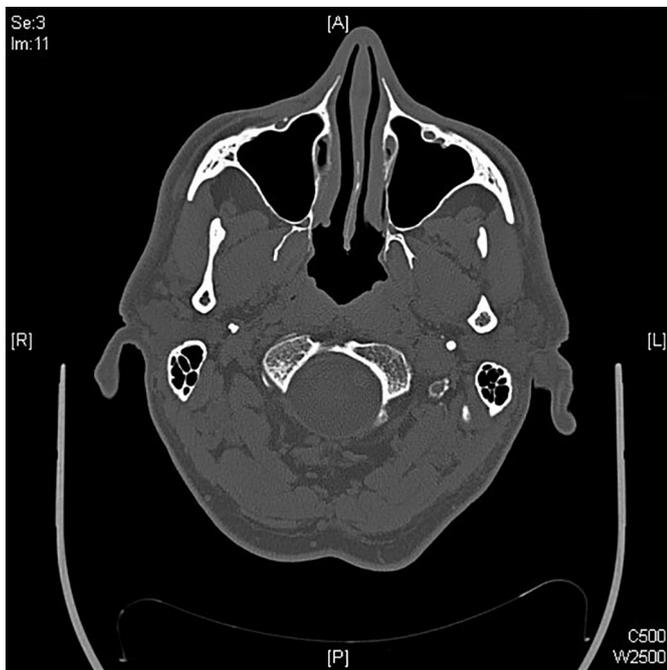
Case 1: CT scan showing the excision (absence) of the previous formation shown in Fig. 1.
